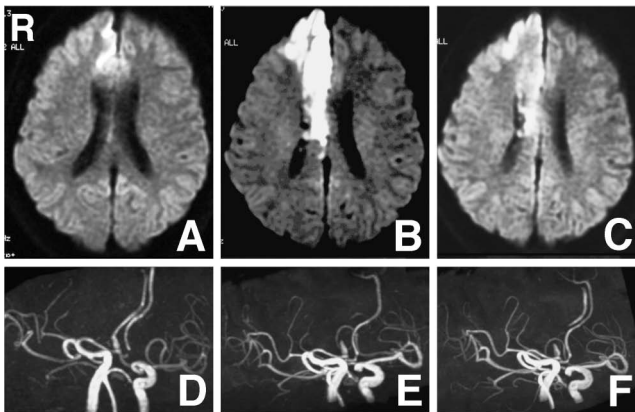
Diffusion-weighted magnetic resonance (MR) image on admission demonstrating cerebral infarction in the territory of the right anterior cerebral artery (ACA) (A), and MR angiogram showing the aneurysmal dilatation (D). Diffusion-weighted MR image on day 2 demonstrating enlargement of ischemic lesion in the territory of the right ACA (B), and MR angiogram showing the right A₂ was occluded (E). Diffusion-weighted MR image on day 9 demonstrating no expansion of cerebral infarction (C), and MR angiogram showing the reperfusion of the right ACA (F).
